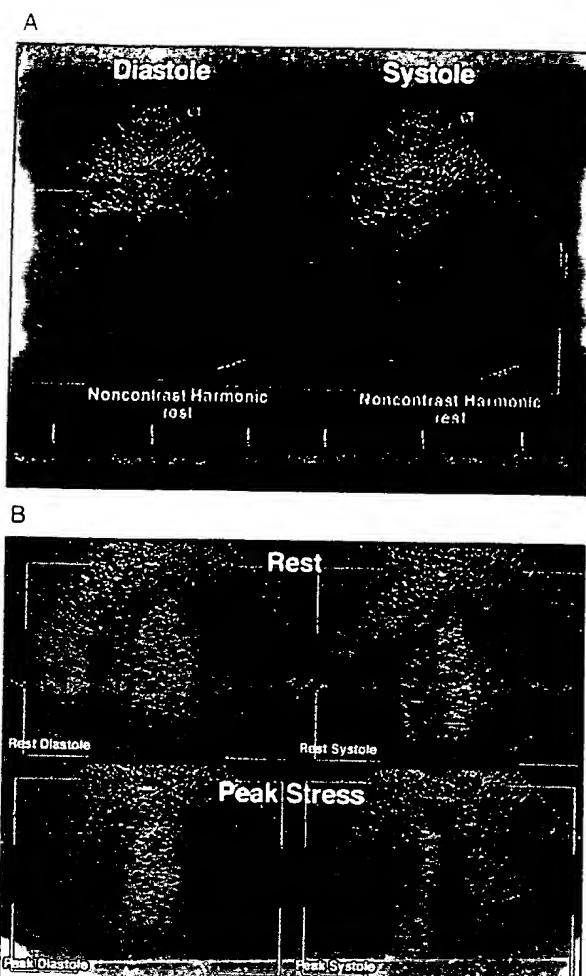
Second harmonic images from a patient undergoing stress echocardiography. The resting noncontrast images (A) are completely uninterpretable. After Optison (B), the rest and stress images show complete left-ventricular opacification and endocardial delineation, demonstrating normal wall motion.
